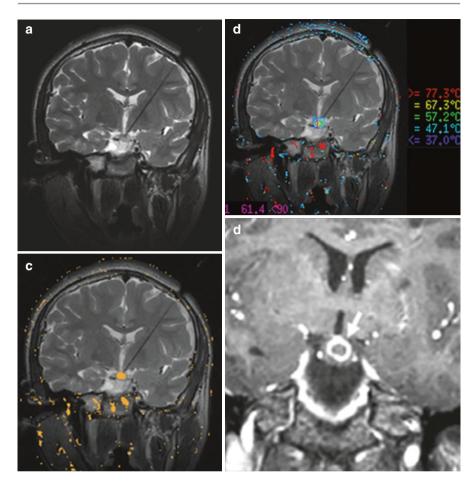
Representative imaging acquired during surgical treatment of HH with stereotactic MRI-guided laser thermoablation. (a) Coronal T2-weighted image showing successful placement of the laser ablation probe into the HH, entering the skull from a burr hole over the left cerebral convexity. This trajectory is individualized to avoid major vessels and to minimize the risk of injury to sensitive structures (such as the internal capsule). (b) Stereotactic laser thermoablation makes use of near-real-time MR thermography to superimpose the thermal signal onto the structural imaging (coronal T2-weighted). Predetermined safety points for maximal temperature are entered into the treatment program to minimize the risk of thermal injury to normal surrounding structures (such as the optic tracts). In this way the system will shut down if one of these safety parameters is breached during treatment. (c) Predicted region of thermal injury (zone of predicted cell death based upon MR thermography) is represented in yellow on this coronal T2-weighted sequence. (d) Postoperative coronal T1-weighted image with contrast administration showing ring-enhancing region of cellular injury within the HH after thermoablation treatment
